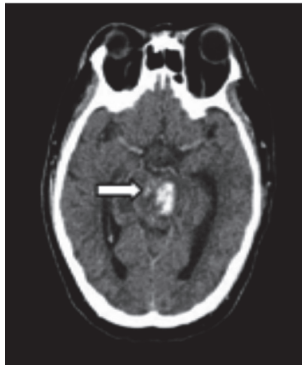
(B): Axial Plain CT Brain Image Showing the Midbrain Extending into the Fourth Ventricle and Prepontine Cistern
